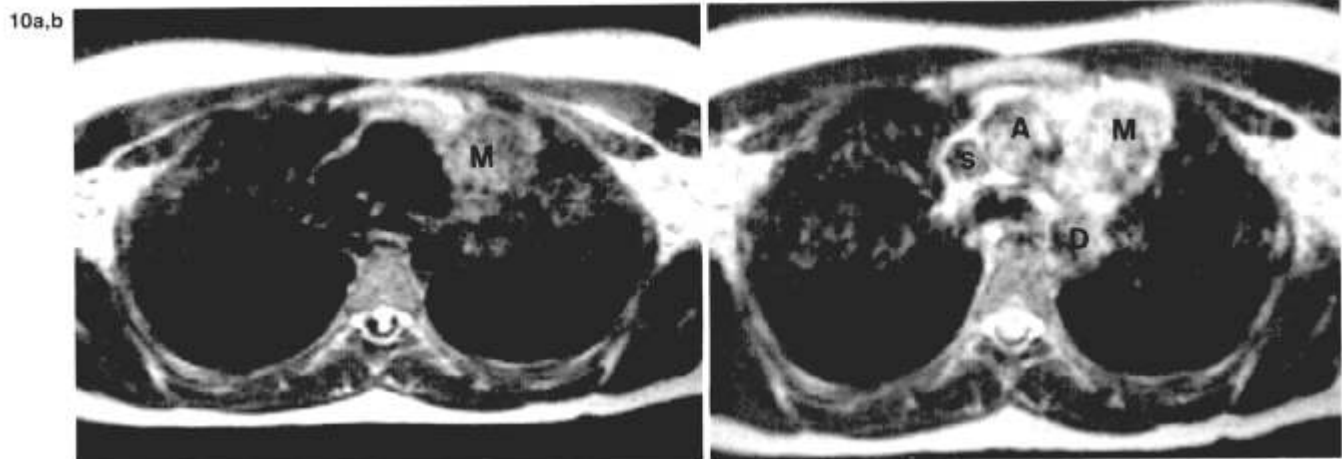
a: T2-weighted SE image (TR 2,000/TE 100) near level of carina. Mass (M) in left anterior thorax is from Hodgkin lymphoma. b: Motion artifact suppression technique (MAST) image at same level. Note intermediate signal intensity within the great vessels and enhanced interfaces within the mediastinum. M, mass; S, superior vena cava; A, ascending aorta; D, descending aorta.
